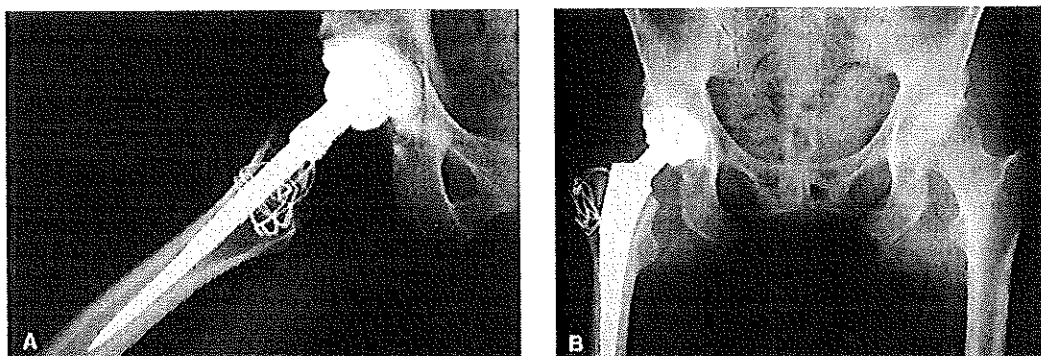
(A) AP radiograph of implanted Trilock stem (DePuy). The tapering of the stem into the diaphysis with excellent mediolateral fit can be seen. (B) Lateral radiograph of implanted Trilock stem showing the lack of AP filling of the component within the canal.
